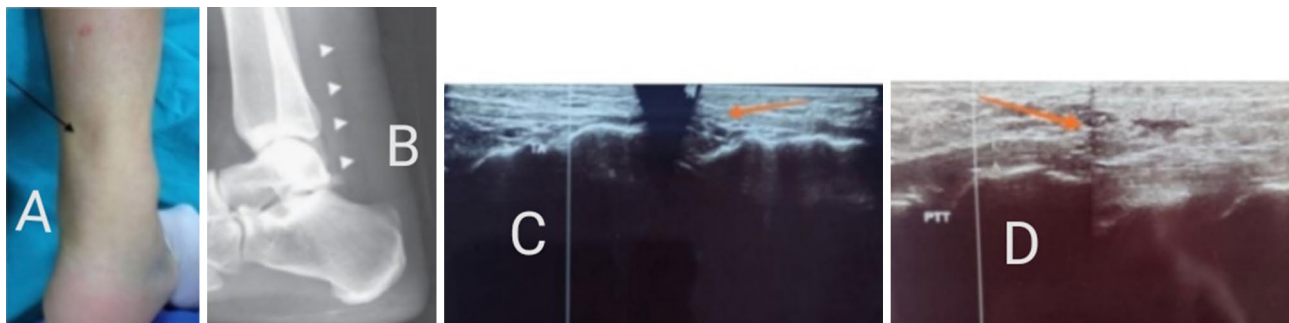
A Visible gap at the rupture site. B X-ray showing obliterated Kager's triangle. C, D Ultrasonography showing ruptured Achilles tendon
